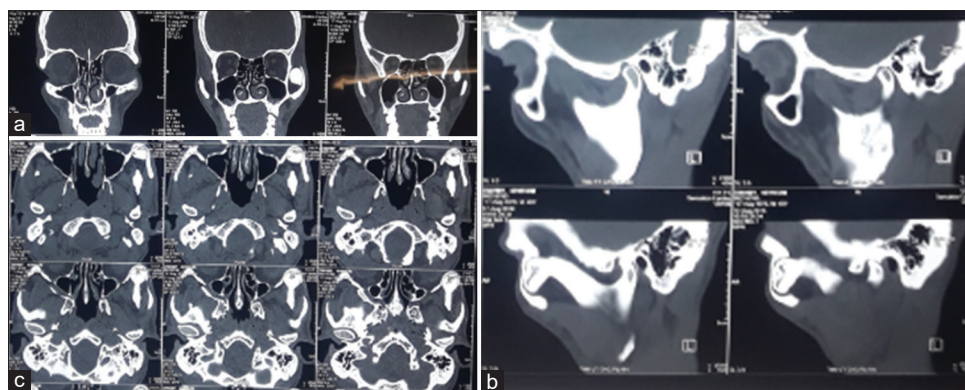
(a) Coronal section of computed tomography face suggestive of a round mass in the left malar region. (b) Sagittal section of noncontrast computed tomography face showing typical horsehead- or mushroom-shaped mass encroaching the left infratemporal region. Note the similarity in the density of the lesion to that of the normal bone. (c) Axial section of the noncontrast computed tomography face showing oval mass impinging on the adjacent arch of the left side
